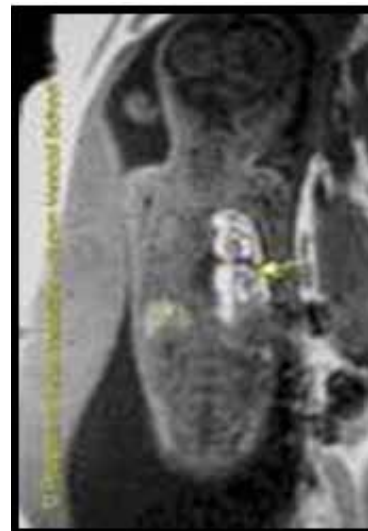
Antenatal MRI scan showing a left CDH at a 32-week scan. Bowel loops are seen in the chest, and there is mediastinal shift.
